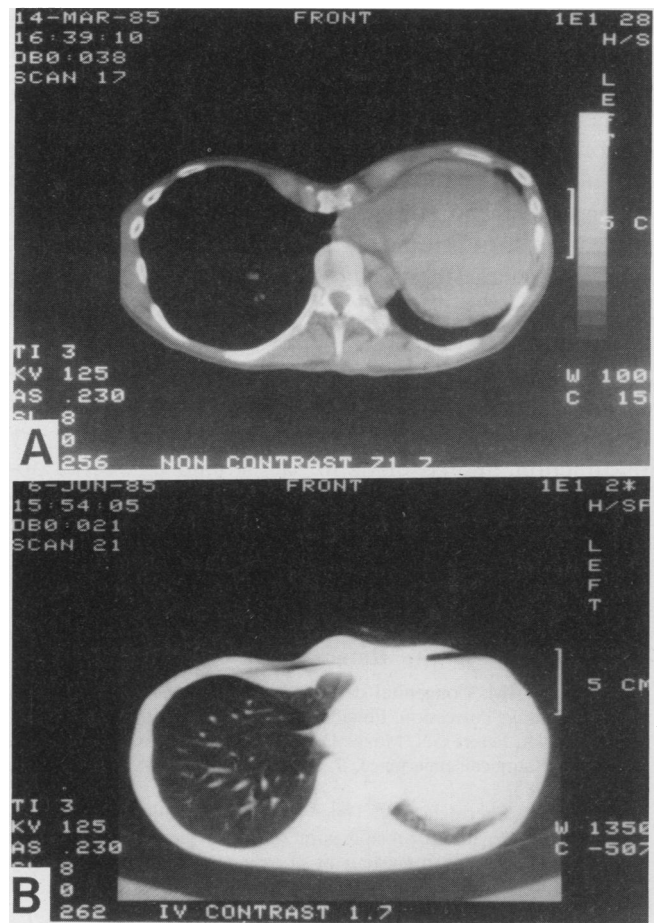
Pre- and postoperative chest CT of pectus excavatum repair. At the same level of the defect, (A) preoperative and (B) postoperative views.
